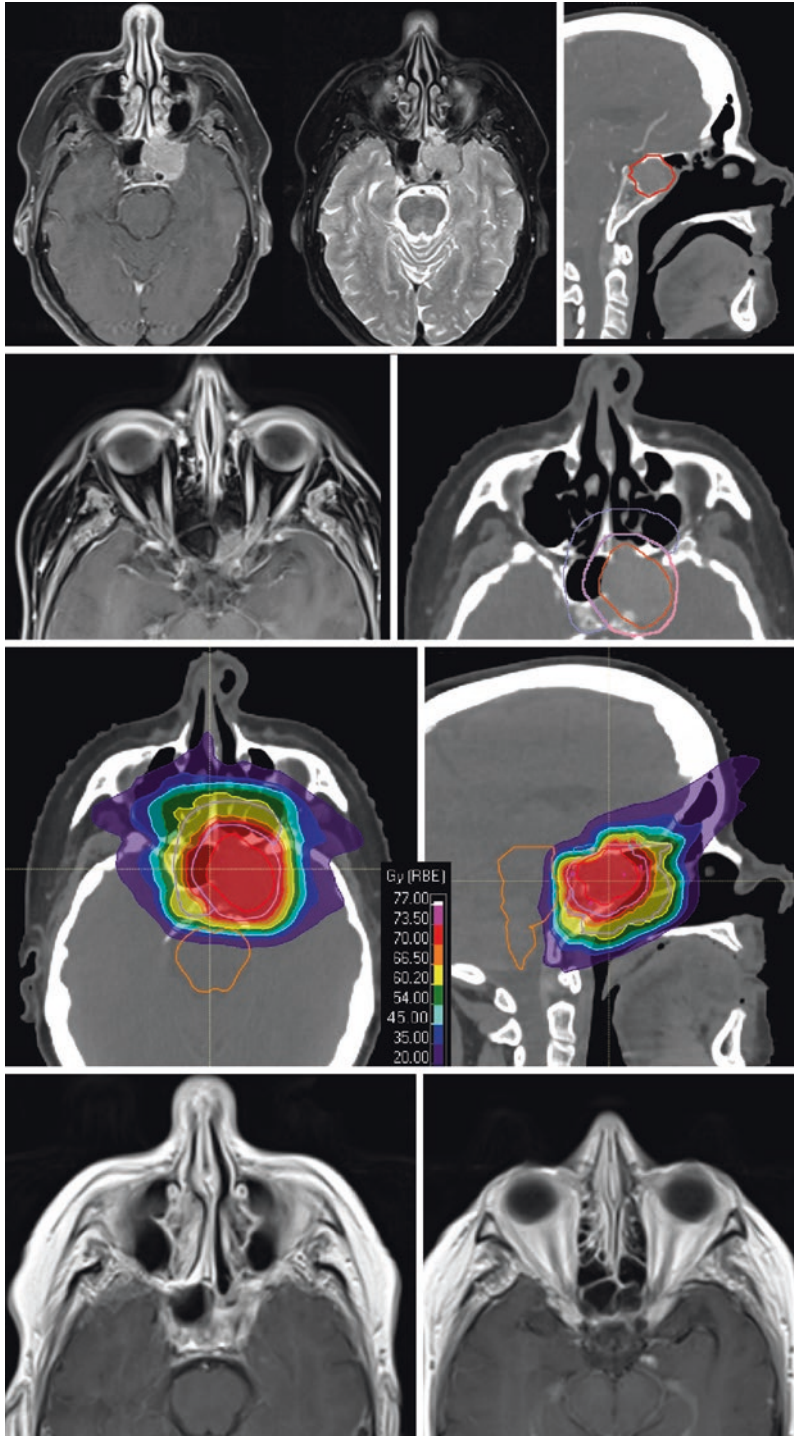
This patient presented with a 2-year history of intermittent epistaxis and CT imaging showed an expansile sphenoid sinus mass. An endoscopic tumor biopsy and debulking showed poorly differentiated squamous cell carcinoma. PET, CT, and MRI showed tumor involvement of the left cavernous sinus, the medial margin of the superior orbital fissure, floor of the anterior clinoid, and widening of the foramen rotundum and sphenopalatine foramen. The MRI on the second row shows the disease on either side of the left optic nerve. The tumor was deemed not reasonably resectable and concurrent chemoradiation was offered. The second row CT image shows the gross tumor volume (red), the clinical target volume to receive 70 Gy (pink) and an intermediate volume to receive 60 Gy (purple). The proton colorwash is shown on the third row. Because of the disease extent, it was not possible to spare the left optic nerve and the patient was informed of and consented to an expectation of eventual vision loss in the left eye. While the mean dose to the left optic nerve was 54 Gy, 29% of the nerve received a dose of 70 Gy. The optic chiasm and right optic nerve constraints were met to avoid risk of bilateral vision loss. Because the tumor did not involve the nasopharyngeal mucosa, only the primary site was treated, without elective nodal irradiation. A complete response was noted on PET/CT at 3 months post-treatment. At 14 months post-treatment a small focus of enhancement was noted in the left medial temporal lobe/uncus consistent with asymptomatic (grade 1) radiation necrosis. In an effort to prevent progression to potentially symptomatic necrosis, pentoxifylline with vitamin E was recommended, but the patient preferred not to take it. The bottom row shows an MRI 18 months after completion of treatment with stable post-treatment changes and no change in the area of necrosis. The patient retained normal vision at 2 years after treatment
